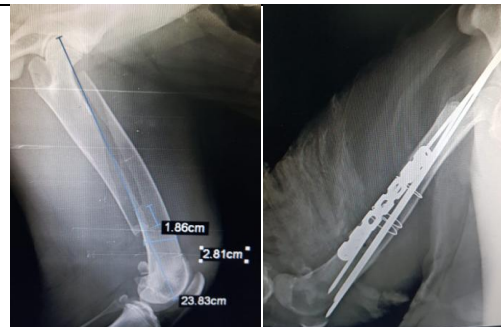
Preoperative and 15-days postoperative radiograph (Case_7)
